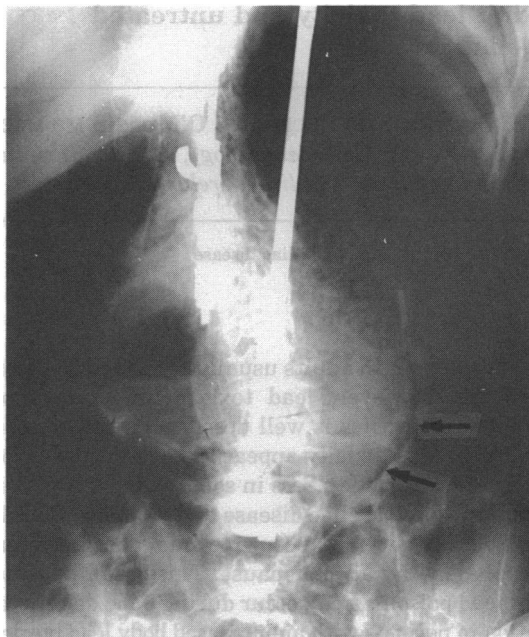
Ehlers-Danlos syndrome with spinal instrumentation. Plain X-ray shows dilated stomach with food debris and intramural gas (arrows)
